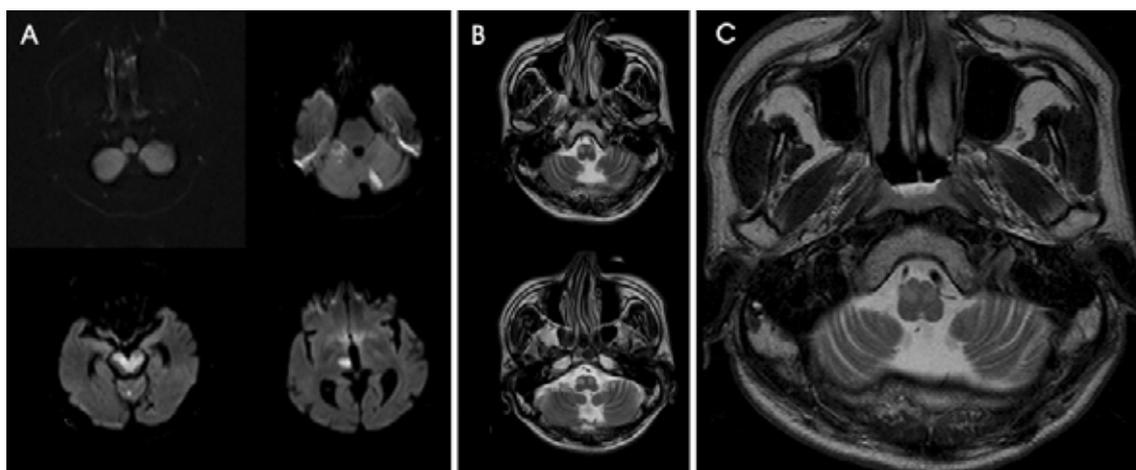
MRI findings at the onset of infarction (A). Acute infarction was observed in the bilateral midbrain, right median thalamus, and superior cerebellum. Follow-up T2-weighted MRI performed four months later revealed bilateral olivary hypertrophy (B). T2-weighted MRI performed eight months after the infarction revealed persistent olivary hypertrophy (C).
